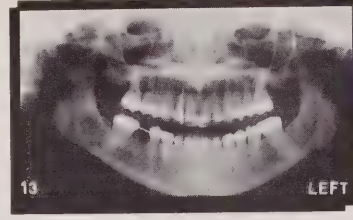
Progress panoramic radiograph (molar uprighting).
